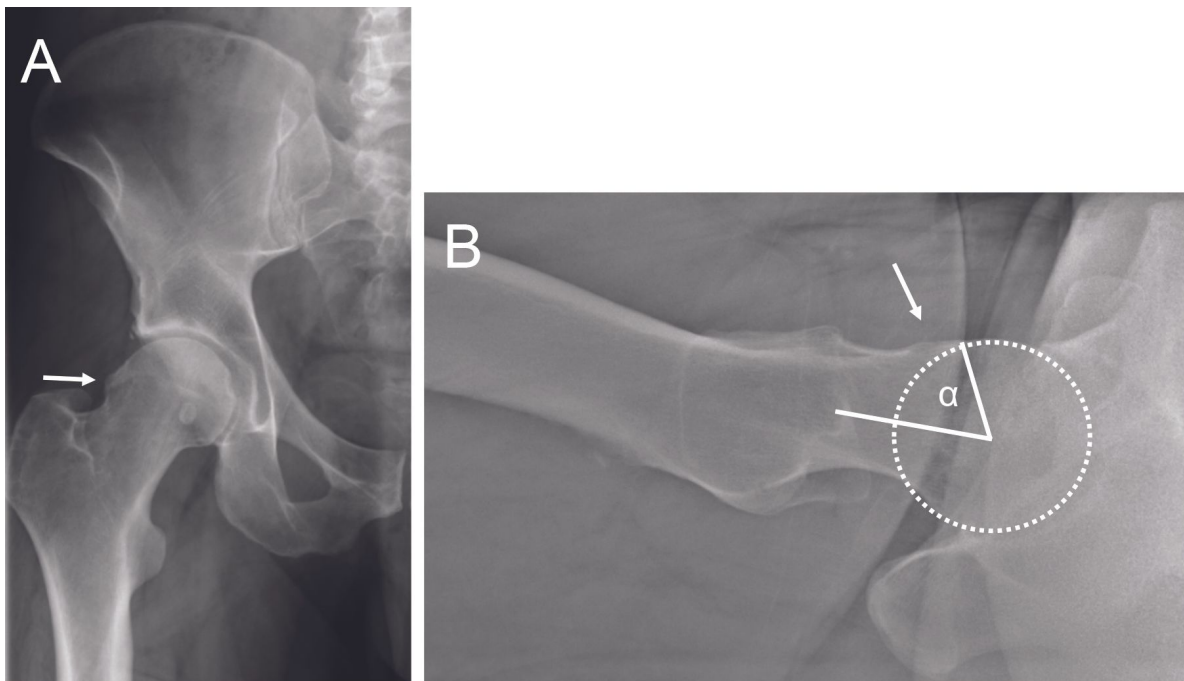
Cam effect The filling of the cervical-cephalic junction, which causes a cam-type femoro-acetabular impingement (white arrow), can be seen on the frontal (A) and axial (B) pelvis radiographs. The alpha angle can be measured on the axial view and is elevated in cam type impingement.
